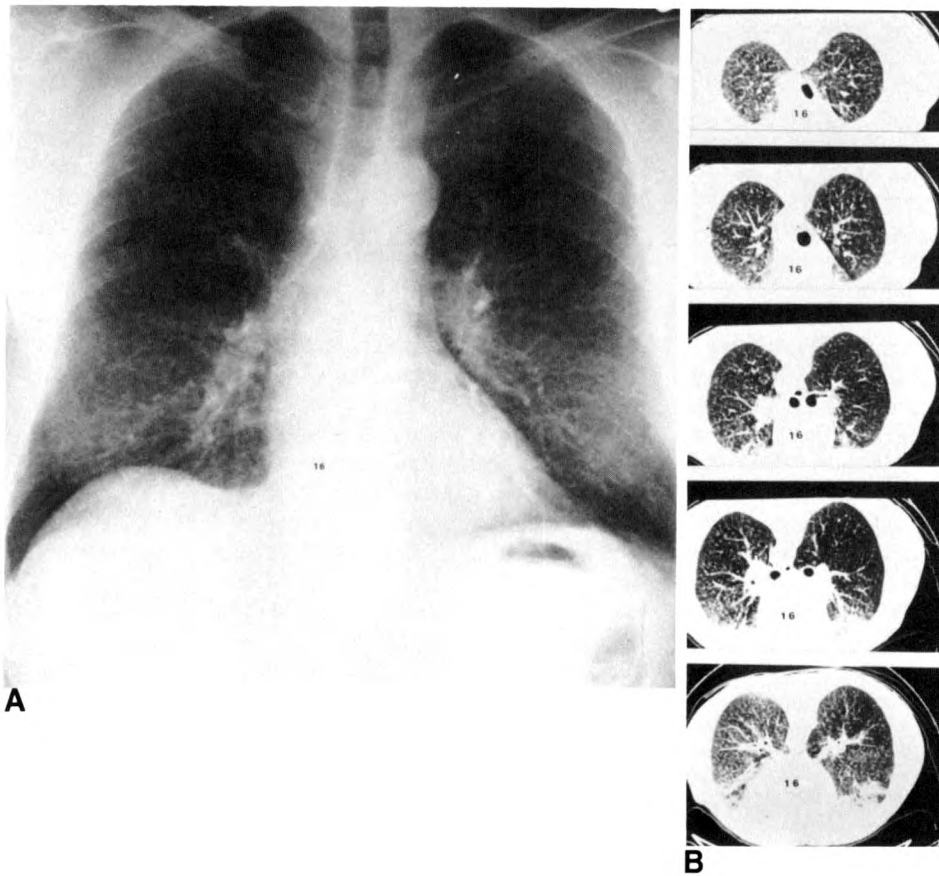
Chest radiograph (A) and CT scans (B) in patient with simple silicosis. The findings are similar in both methods. The opacities are distributed more evenly throughout the lungs than in Fig. 2.
